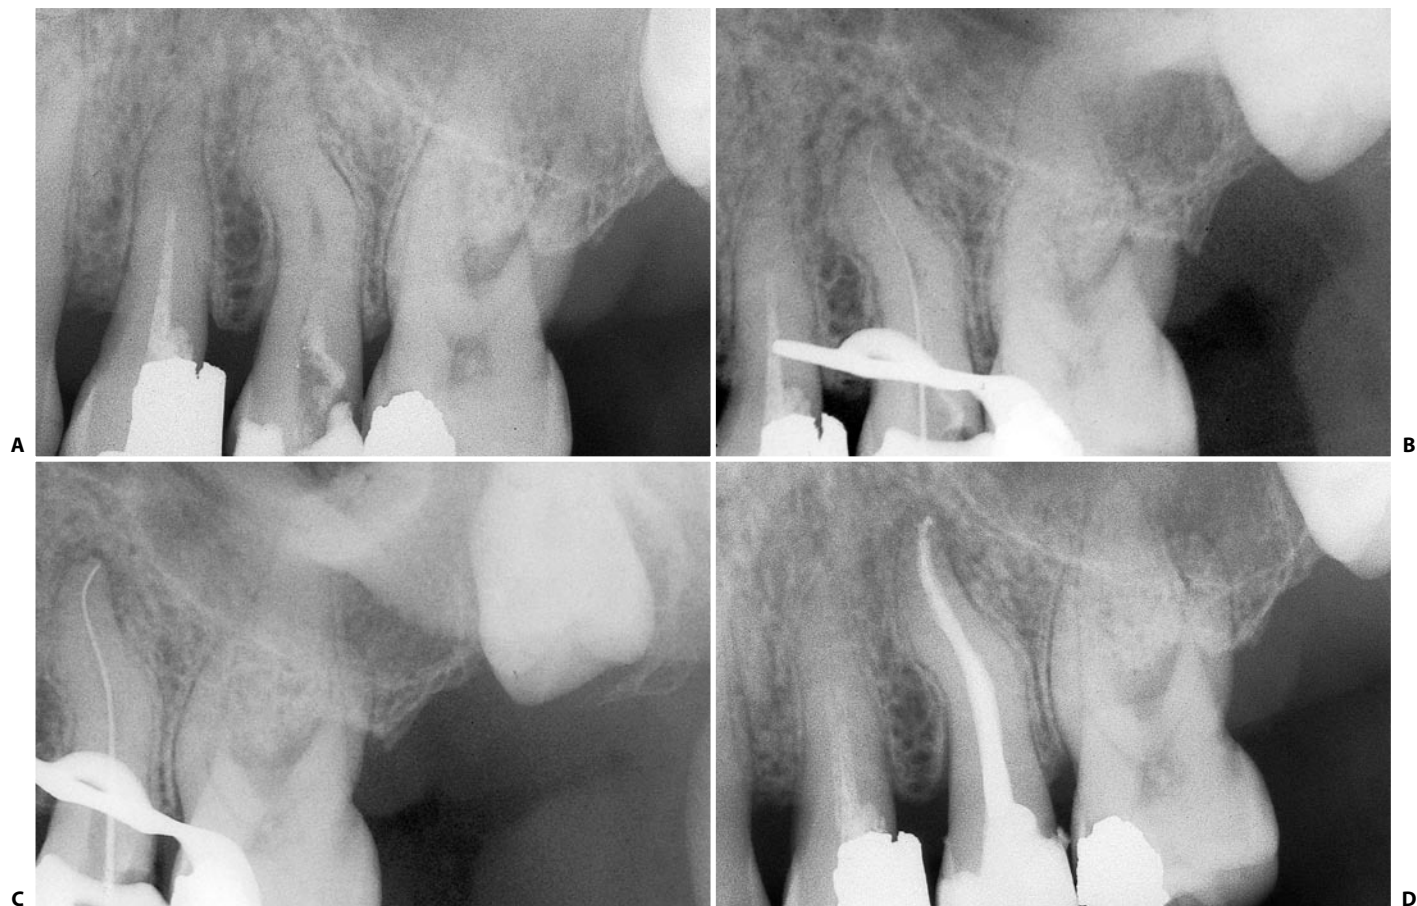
An upper left second premolar with a bayonet curve. Note the preservation of the position of the foramen and the slight blunting of the two curves. A. Preoperative radiograph. B. Intraoperative radiograph with the first instrument at the radiographic terminus of the canal. C. Intraoperative radiograph with the last instrument at the radiographic terminus of the canal. D. Postoperative radiograph.
